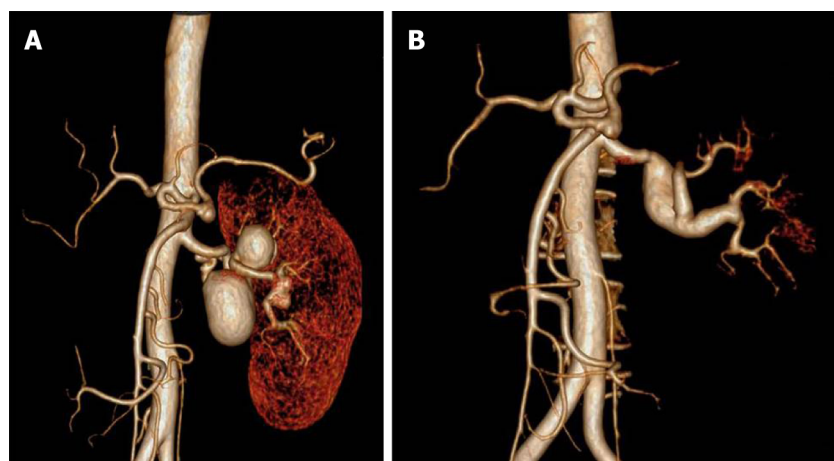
Computed tomography angiography. A: Preoperative computed tomography angiography. Triple complicated multiple renal artery aneurysms with a maximum size of 4 cm, distal renal artery bifurcation, and branches were involved; B: Three-year follow-up computed tomography angiography. The saphenous vein graft was patent with aneurysmal degeneration.
